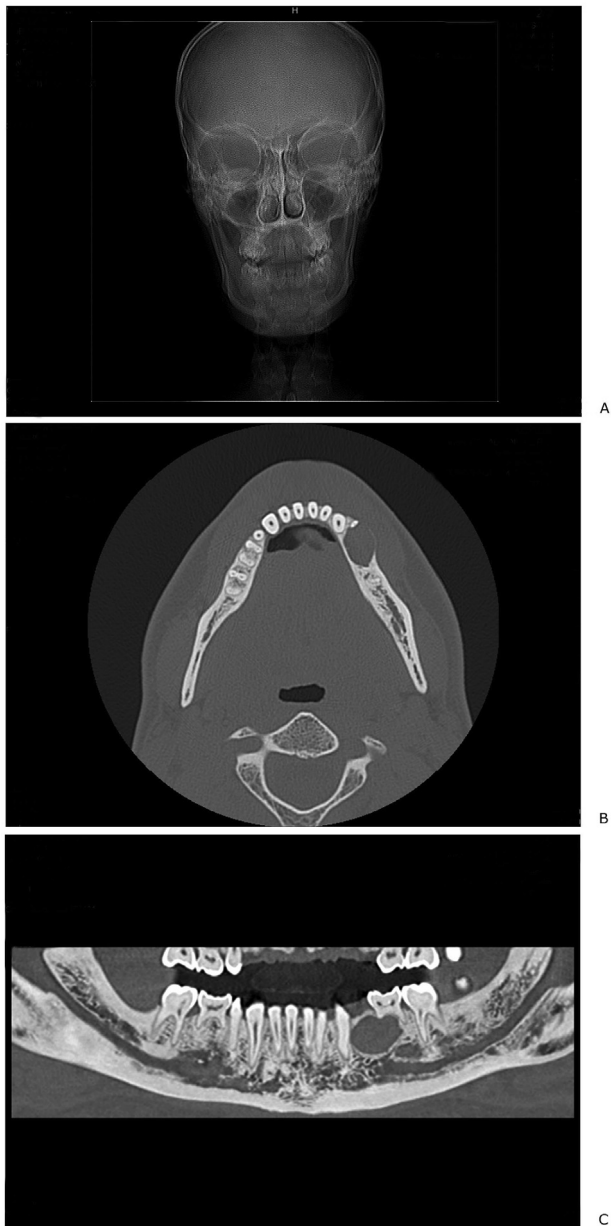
Case #2: Radiology showing left mandibular ameloblastoma. (A) X-ray. (B) Axial and (C) coronal CT scan.
